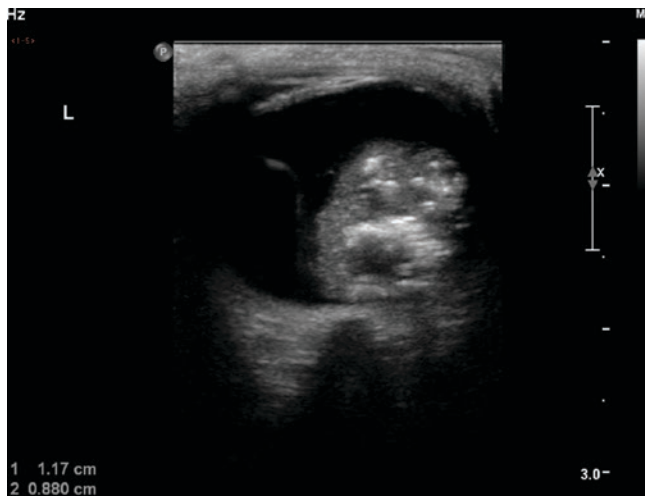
Retinoblastoma. Transverse ultrasound image demonstrates an irregular, echogenic soft-tissue structure posteriorly in the left globe. Small foci of hyperechogenicity within the tumour represent calcification
